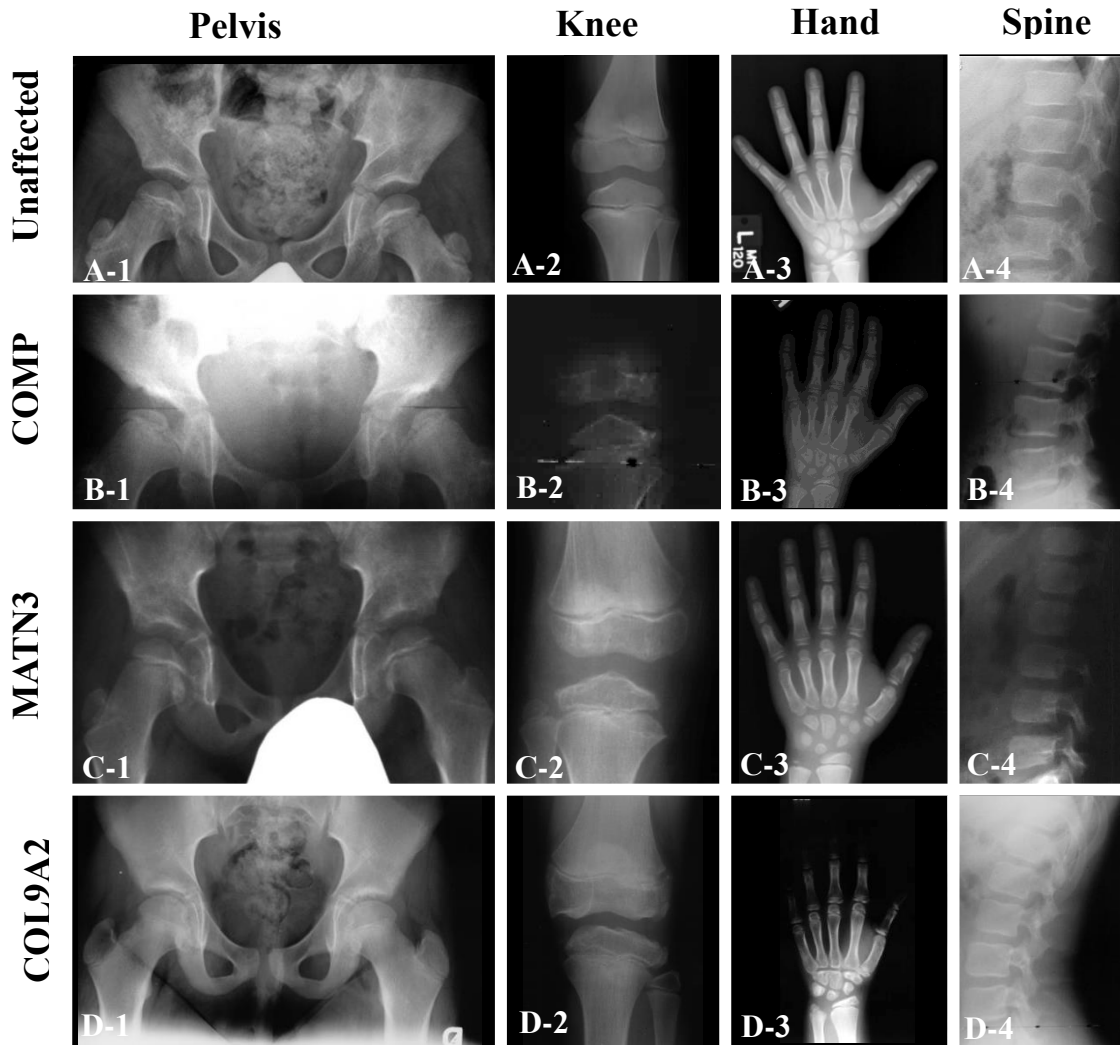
Radiographic Phenotype of MED Patients with Mutations in *COMP*, *MATN3*, and *COL9A2*. A) Adolescent films from an unaffected individual. A-1. AP pelvis at age 9. A-2. AP knee (Figure A-2 is modified from Boeyer and Ousley 2016 [62]). A-3. AP hand at age 12. A-4. Lateral spine at age 12. B) Patient R95-334A at age 13, positive for *COMP* p.Asp317Asn mutation B-1. Pelvis has small, irregularly-shaped capital femoral epiphyses with flat, under-modeled acetabulum and abnormal metaphyses of the proximal femurs. B-2. Knee epiphyses are flat and small B-3. Hand phenotype is severe with brachydactyly, irregularly-shaped carpal bones with a 2-4 year delay in ossification, and poorly ossified distal phalanges. B-4. Vertebral bodies are mildly anteriorly rounded. C) Patient R95-055A at age 8, positive for *MATN3* p.Ile109Lys mutation. C-1. AP pelvis showing that capital femoral epiphyses are irregularly-shaped with metaphyseal irregularities. Acetabular roof is relatively normal. C-2. AP knee showing that the proximal tibial knee epiphyses are small, short, and flat with abnormal metaphyses. C-3. AP hand is relatively normal with no brachydactyly but advanced carpal ossification was observed. C-4. Lateral spine showing that vertebral bodies that are mildly rounded and a little flat, but
